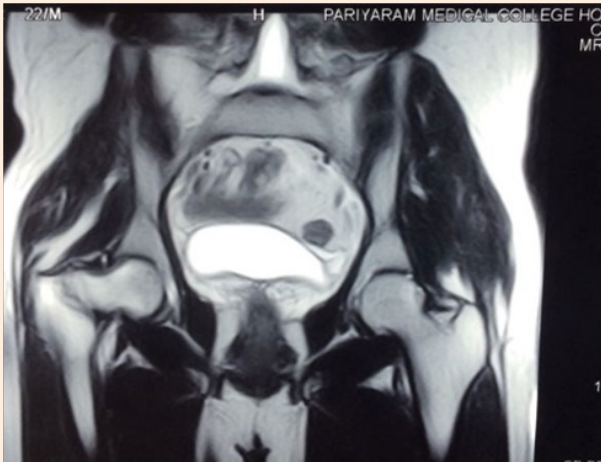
MRI of pelvis showing viability of Right femoral head.
